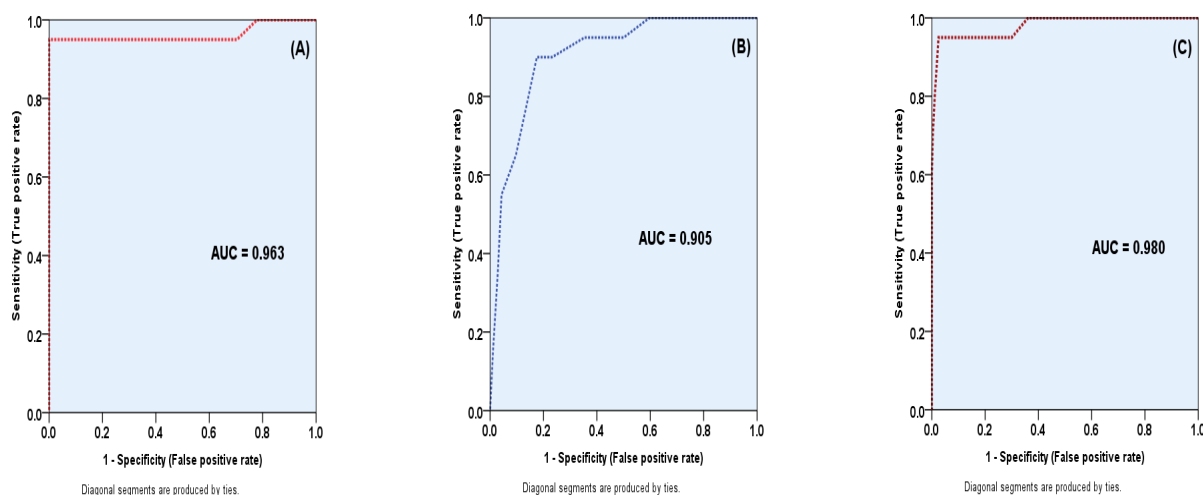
Receiver operating characteristics (ROC) curves for the validity of CT scanning (A), GCS (B) and combined CT & GCS (C), in prediction of cervical injuries. AUC: (Area Under Curve).
